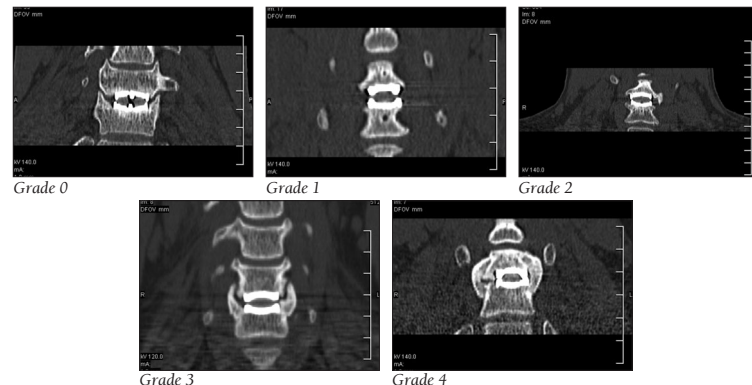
Sample coronal CT scan reformations corresponding to the authors' proposed radiographic scoring system for paravertebral bone formation following total cervical disc replacement.
